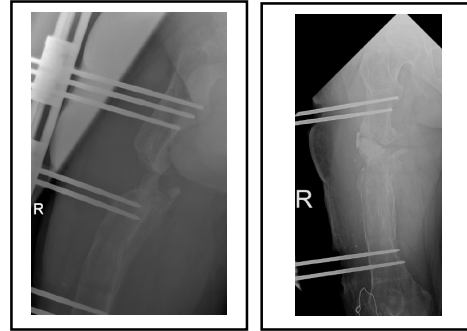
Initial radiograph showing a 2 cm critical bone defect of right femur.
